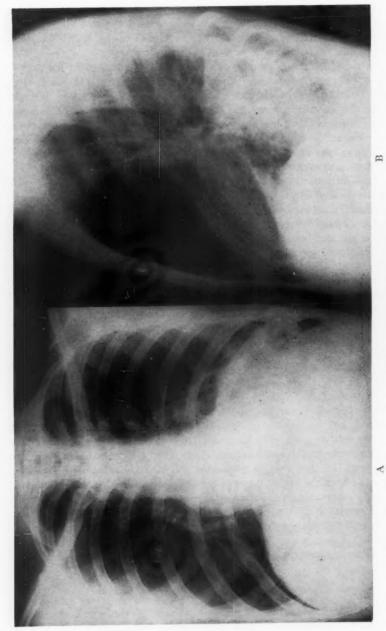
A. Case 1. Roentgenograms of chest taken January 7, 1955. E.P.A. showing 5 cm., thick-walled cyst in apex of left lower lobe and associated homogeneous density situated medially. B. Left lateral showing lesion lying posteriorly.
